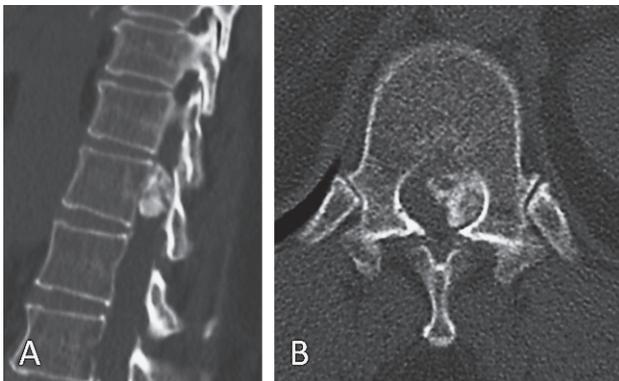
Sagittal CT scan (A) showing an ovoid, high-density area within the spinal canal. An axial section (B) shows the tumor occupying more than half of the spinal canal and pressing the spinal cord laterally.
